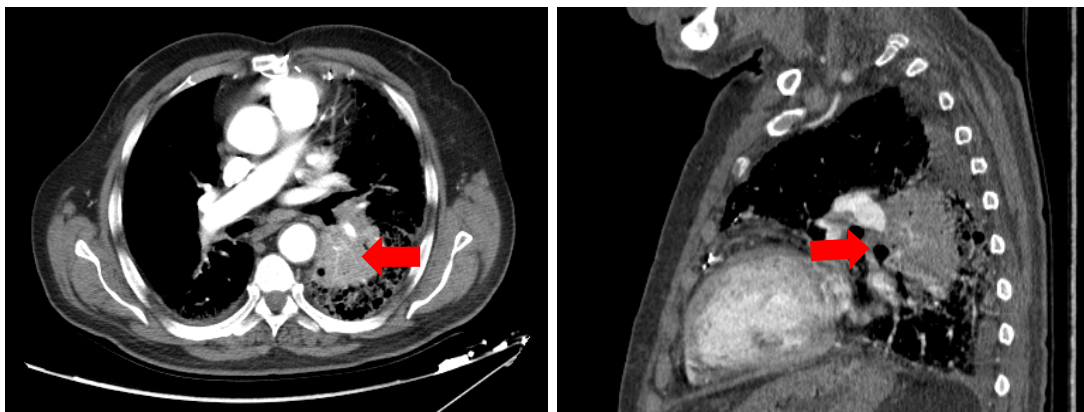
Axial and sagittal computed tomography (CT) scan pulmonary window for 83 years old male demonstrated large mass in the superior segment of left lower lobe (red arrows), later on it proved to be malignant round blue cell tumor by biopsy
